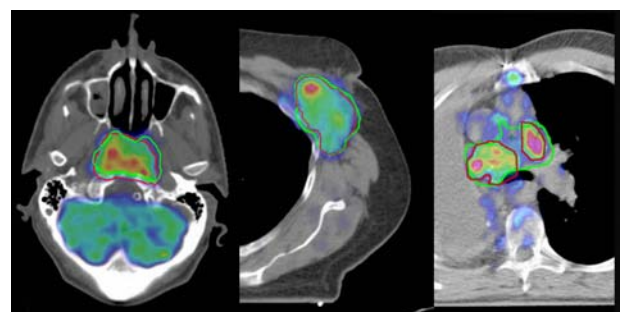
GTV definition for three different sites: green the outline defined by the clinician based on CT, in red the outline automatically defined by the software based on PET data only.
